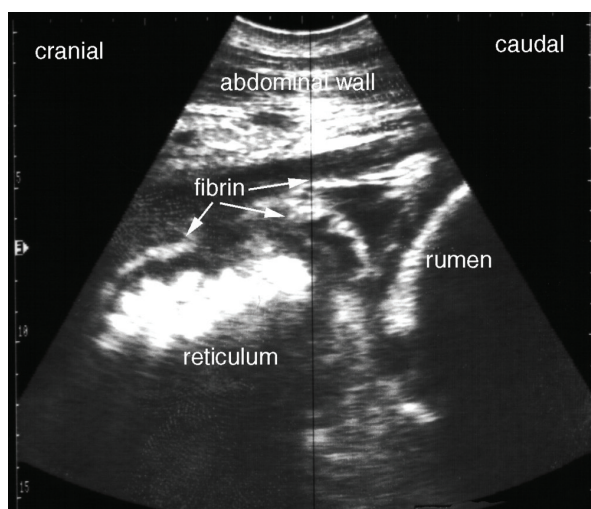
Sonogram of a buffalo (3.5 MHz) with chronic local peritonitis. The ultrasonographic image shows echogenic fibrinous strands between reticulum, rumen, and abdominal wall. Notice the corrugated appearance of the reticular wall
